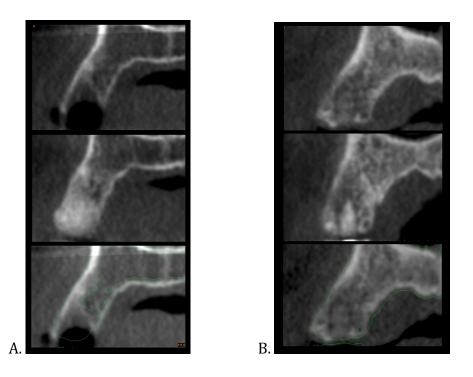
A. Site treated with DBBM at baseline and at 5 months healing. The lower image shows the CBCT superposition and the dimensional changes. B. Baseline and 5-month situation at a site treated with DBBM-C. Dimensional changes can be observed at on the CBCT superposition.
